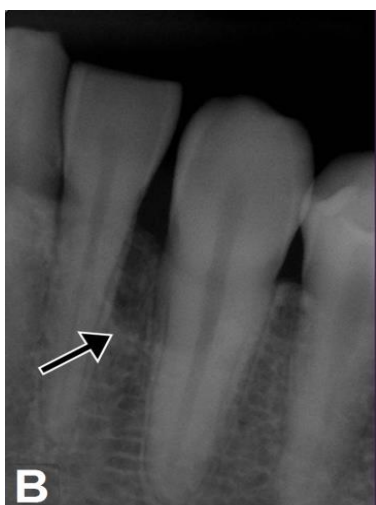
Pre-operative radiograph shows interdental spacing and horizontal bone loss at region between the teeth 32 and 33 (see arrow). (A) Orthopantomograph and (B) Intra-oral periapical.
